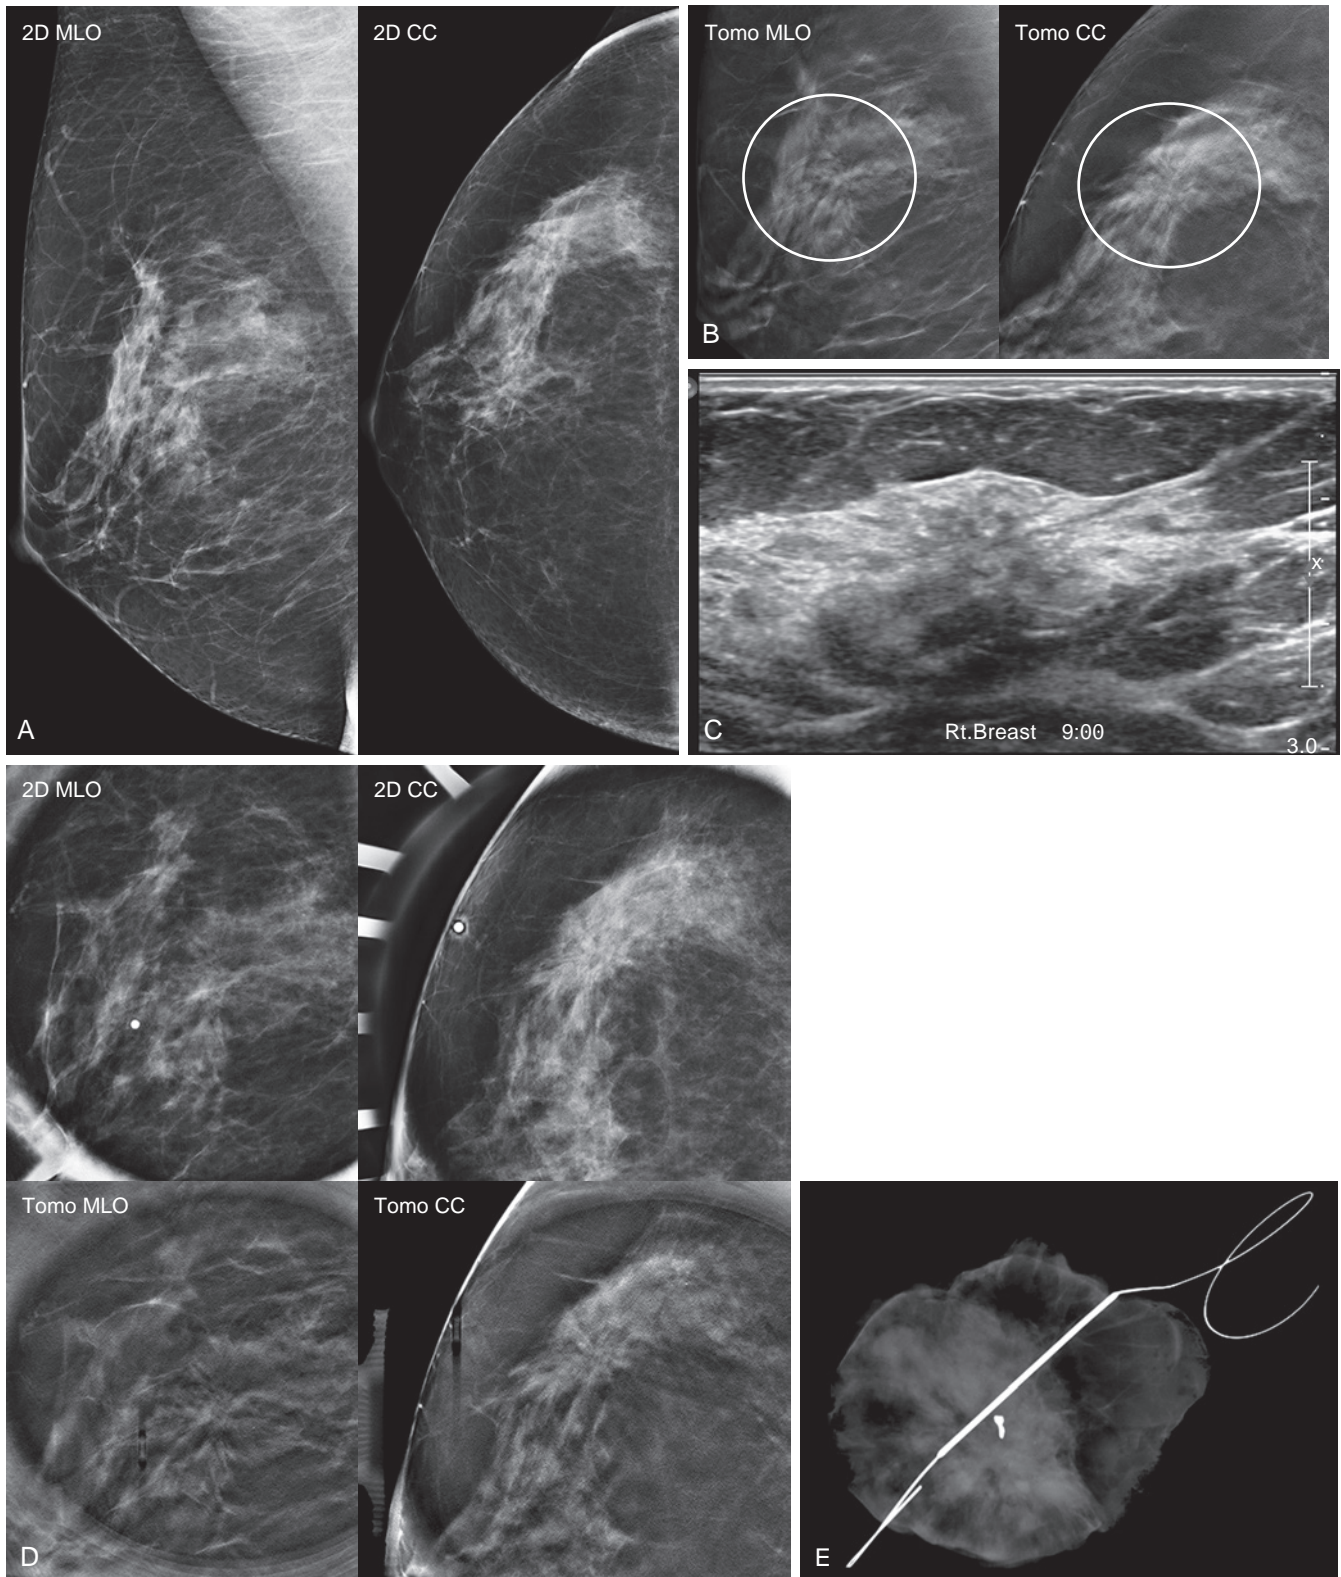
(A) Screening mammogram in a 47-year-old woman shows architectural distortion in the upper-outer right breast best seen on the (B) tomosynthesis views (*circles*). (C) Ultrasound reveals a subtle mixed echogenicity lesion with distortion of the architecture. (D) A BB was placed on the skin overlying the sonographic finding, and tomosynthesis spot views were repeated, proving the sonographic finding corresponded to the mammographic finding. Ultrasound core needle biopsy revealed a complex sclerosing lesion. (E) Final excision revealed a complex sclerosing papillary lesion.
